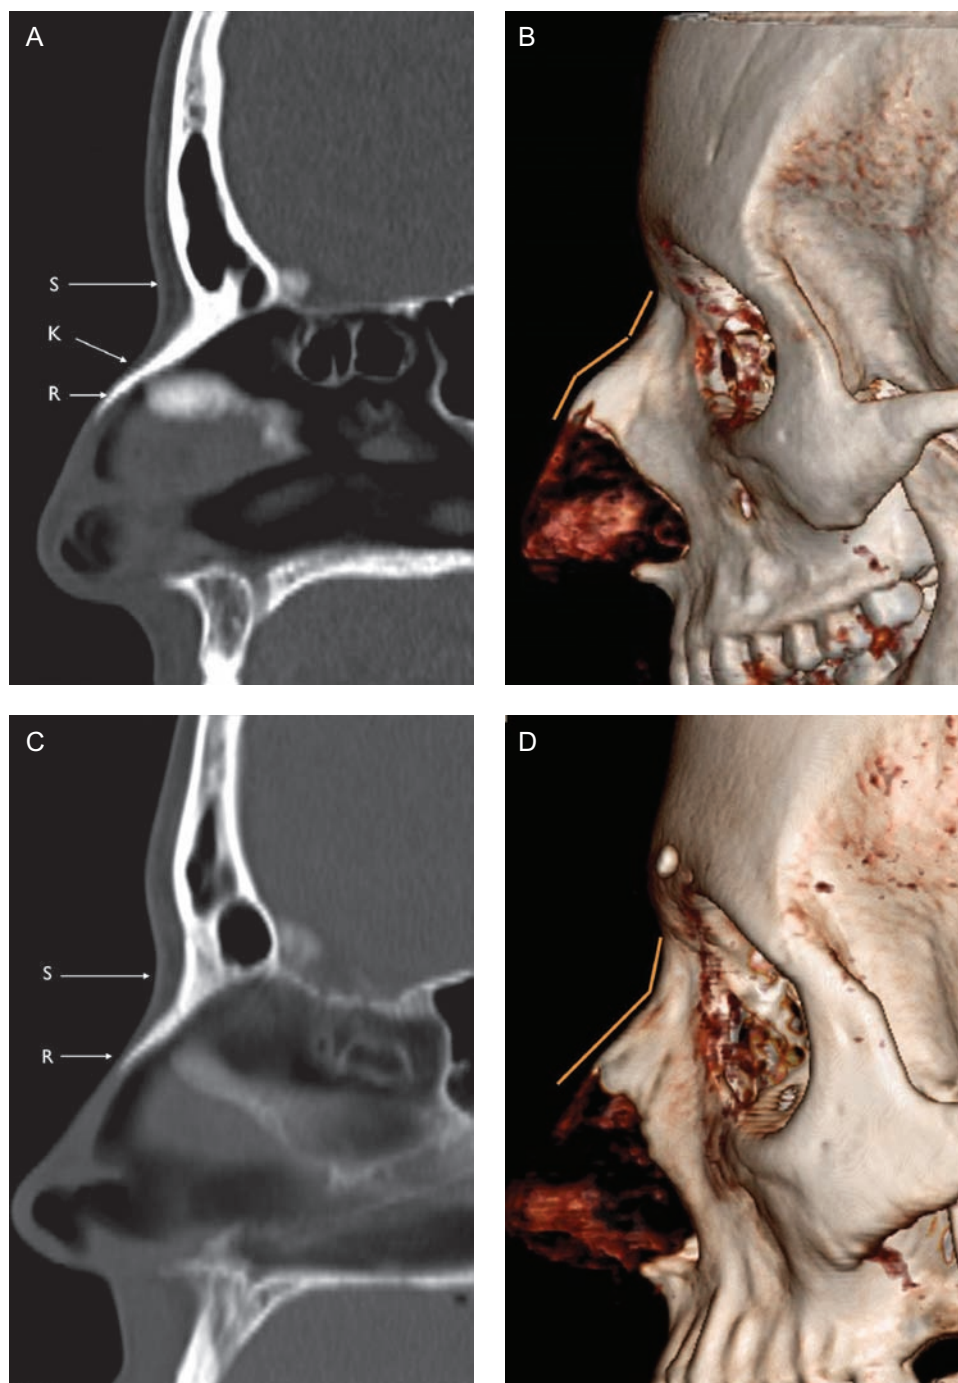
(A) A computed tomography scan of the S-shaped NB of this 42-year-old female patient. (B) A computed tomography scan of a bone reconstruction for the same patient. (C) A computed tomography scan of the V-shaped NB of this 35-year-old male patient. (D) A computed tomography scan of the bone reconstruction for the same patient. S, sellion; K, Khyphion; R, Rhinion.
